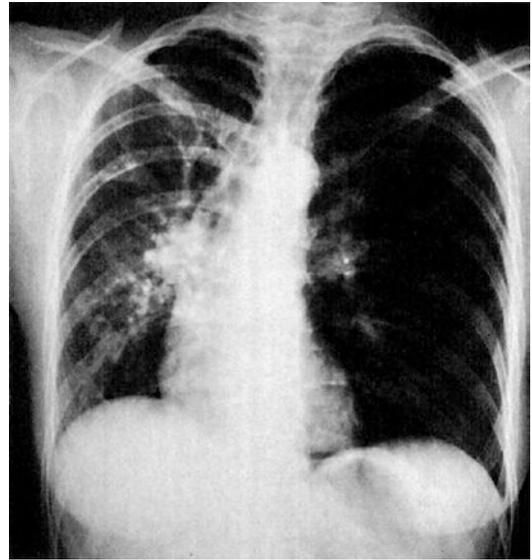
Unilateral left lung asthma. If regional asthma or air trapping is seen, such as on the above radiograph, bronchoscopy is indicated for secretion clearance (From DiFrancis et al. [36]. Reprinted with permission from Elsevier Limited)
